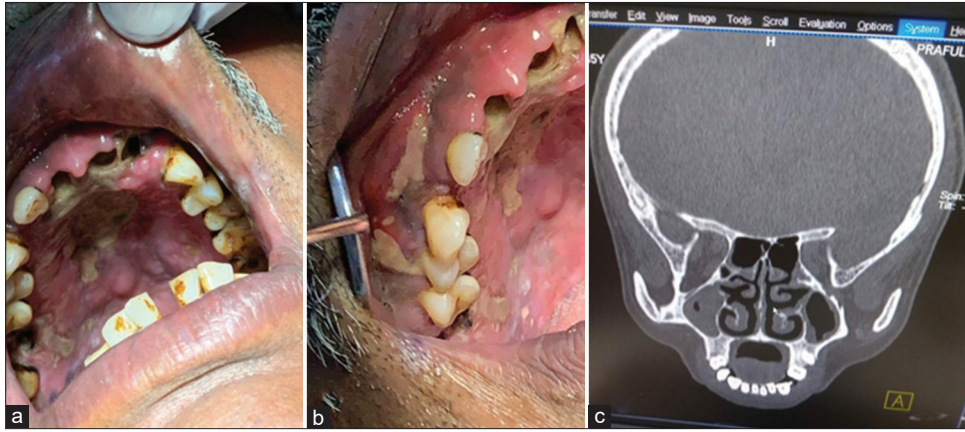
Showing denuded necrotic bone exposure in the (a) anterior maxillary edentulous area and pus discharge in the mid-palatal area; (b) right side of maxilla on buccal side and on palate; and (c) computed tomography scan image shows that hyperdense area in right paranasal sinuses (Case 1)
